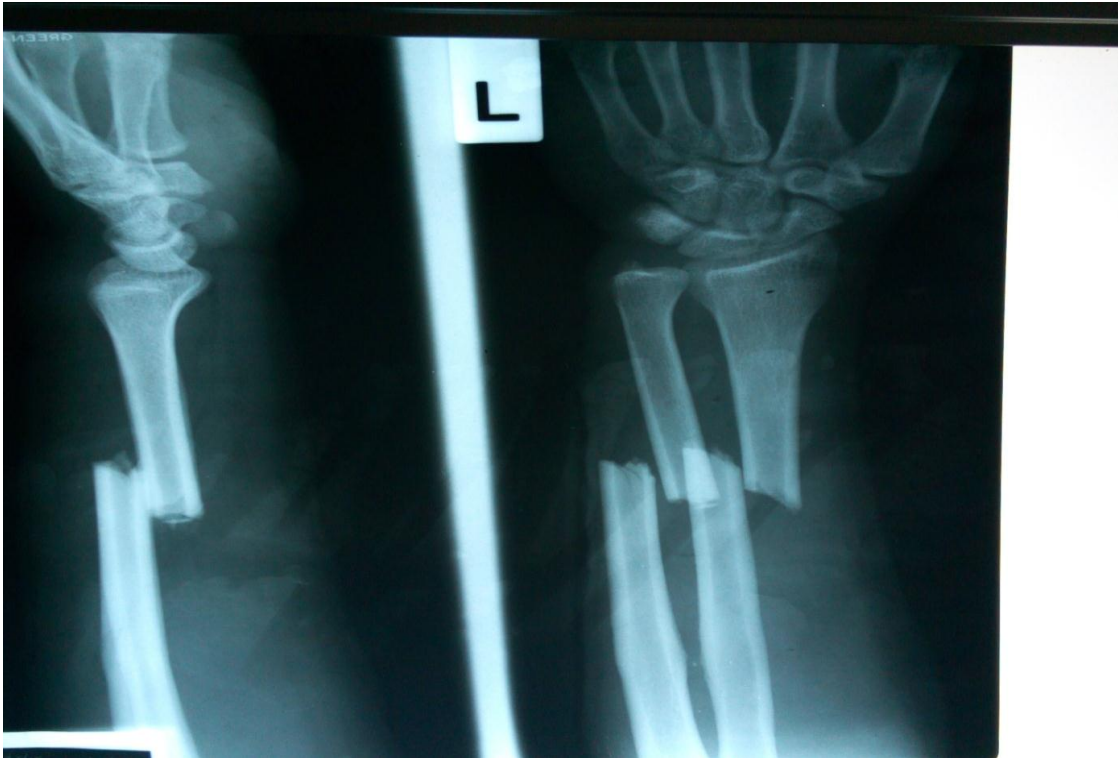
Radiographic image of both bones forearm fractures (22-A3)
